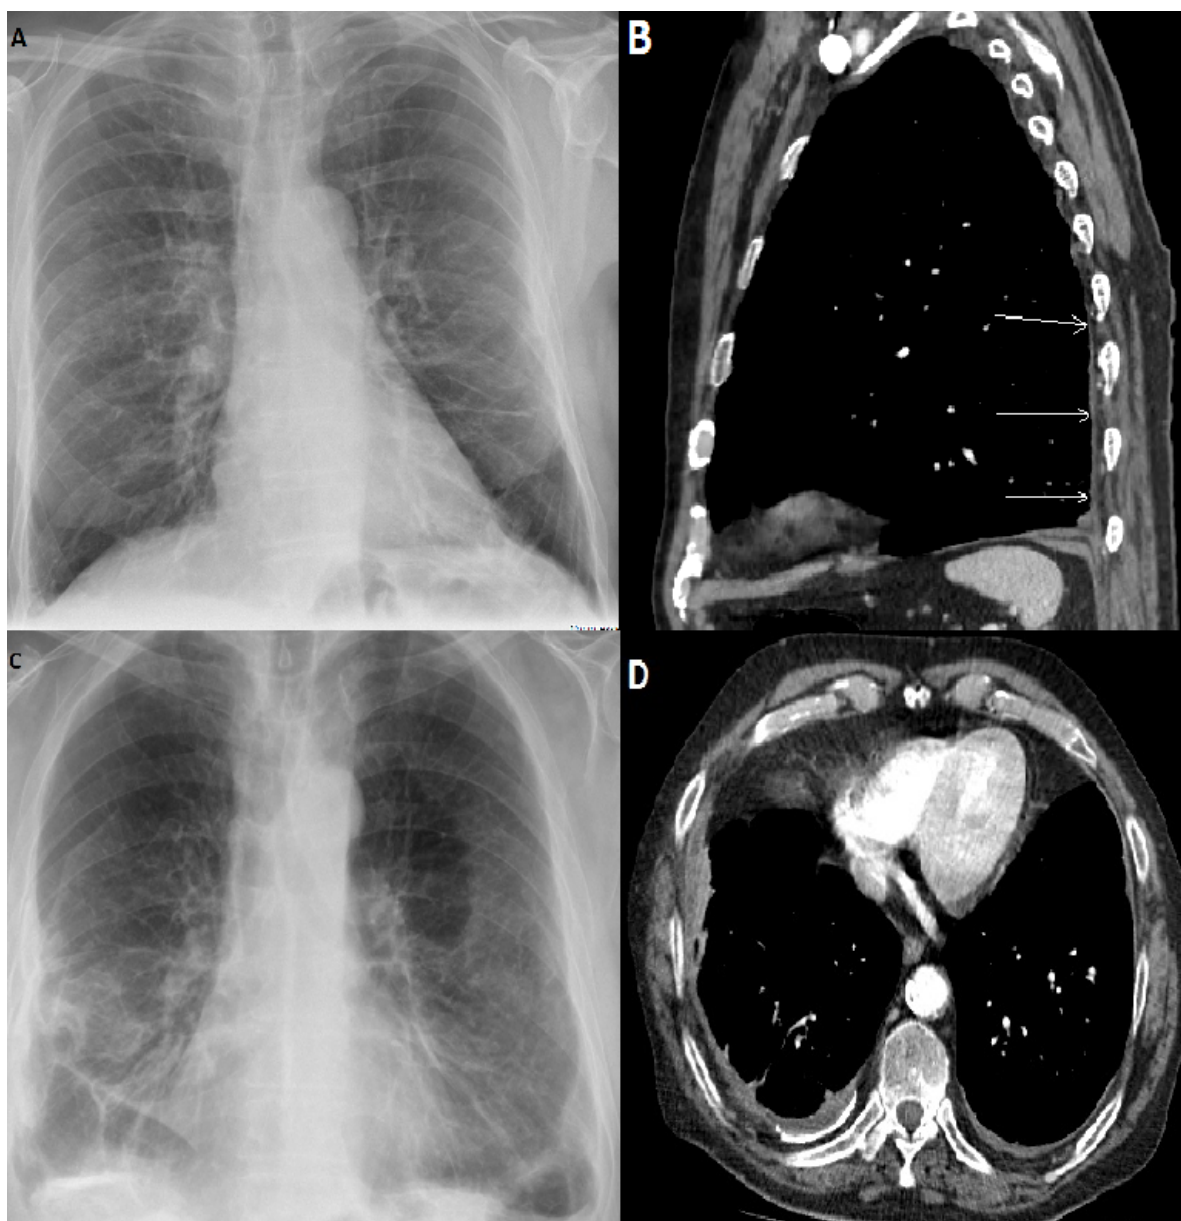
Images of DPT on chest radiograph and CT. Image A shows a postero-anterior chest radiograph of a patient with right sided DPT with no CPA obliteration. Image B is a sagittal CT view of the same patient showing DPT involving the posterior pleura. Image C is a patient with bilateral DPT and CPA obliteration. Image D is an axial image CT image confirming bilateral pleural thickening of same patient.
